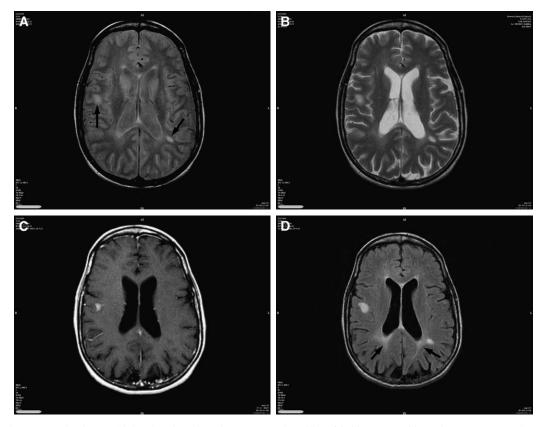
Imaging in a multiple sclerosis patient demonstrates the utility of fluid-attenuated inversion recovery (FLAIR). (A) Proton-weighted T2-weighted (T2W) fast spin echo (FSE) image at the level of the lateral ventricles demonstrates several periventricular white matter lesions (arrows). These are fairly well seen, although smaller lesions can be missed (repetition time [TR] = 3150 milliseconds, echo time [TE] = 10.9 milliseconds). (B) T2W FSE (TR = 3150 milliseconds, TE = 98 milliseconds). The periventricular demyelination is less observable because of adjacent cerebrospinal fluid in the sulci. (C) Axial T1-weighted gadolinium-enhanced (TR = 416 milliseconds, TE = 8.4 milliseconds) spin echo sequence demonstrates an enhancing plaque lesion in the posterior right frontal lobe. Although this sequence is excellent for showing areas of blood-brain barrier breakdown, many of the plaques are not active and hence not visible. (D) Axial fast FLAIR images (TR = 8800 milliseconds, TE = 123 milliseconds, time to inversion [TI] = 2200 milliseconds) reveal the plaques previously identified with the proton-weighted sequence with a much greater degree of conspicuity. In addition, the periventricular white matter disease in the periatrial areas is much more evident (arrows). Also notice the area of vasogenic edema in the posterior right frontal-temporal cortex. The vasogenic edema is larger than the area of blood-brain barrier breakdown seen on the contrast-enhanced images.
